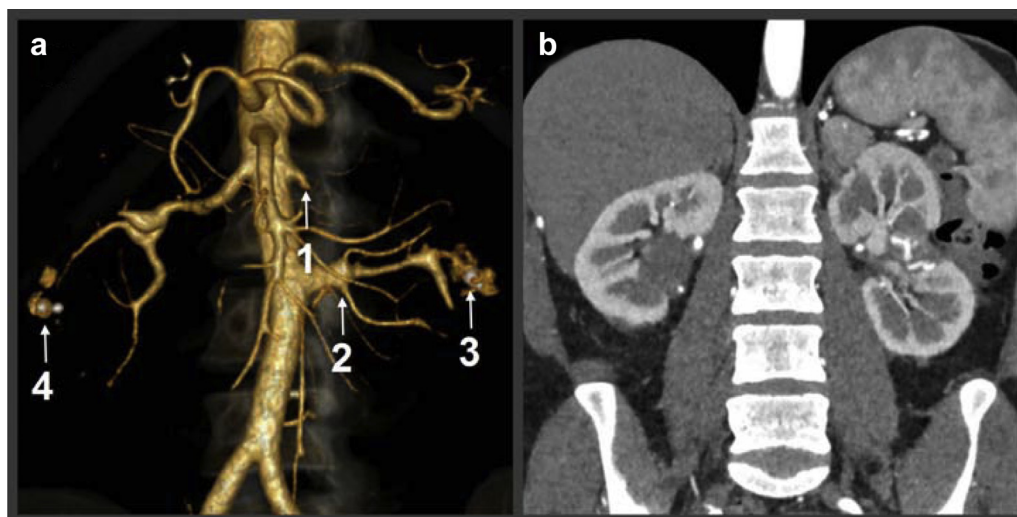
Computed tomography (CT) at 9-months follow-up. a, Volume rendering image demonstrates the optimal surgical result after repair: the stump of the left upper-pole renal artery (1), reimplemented left upper pole renal artery (2); coil (3); and occluder (4). b, Renal parenchyma of both kidneys shows normal enhancement, there is only a small scar in the middle third of the left kidney.
